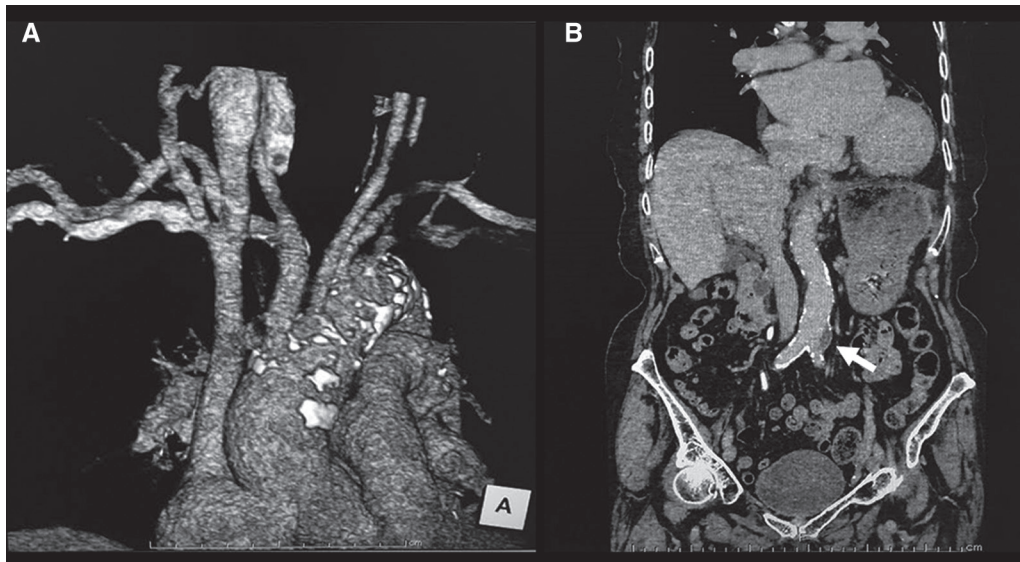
Evaluation of the access route by CT of the thoracoabdominal pelvic region (plain CT performed immediately after CTA of the head). (A) Frontal view of 3D image of the aortic arch (volume rendering). The aortic arch was Type 3 and calcification of the aortic arch was marked. (B) Coronal view of the thoracoabdominal pelvic region. The abdominal aorta was strongly tortuous and calcified, and findings of chronic dissection were partially noted. CTA: computed tomography angiography
